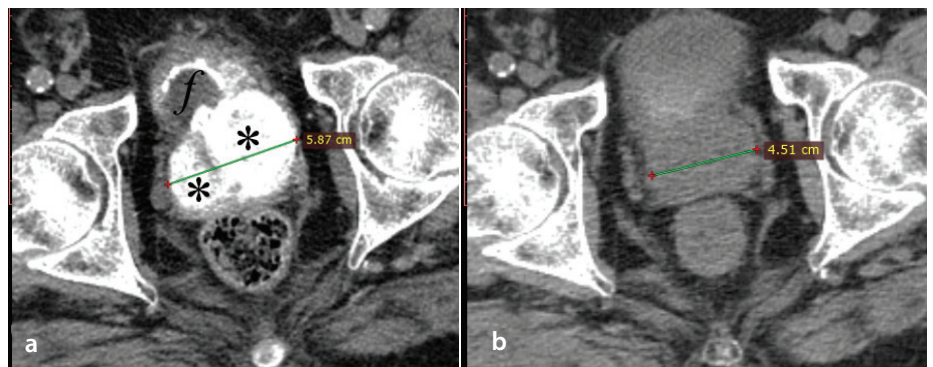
(Images published after patient's informed consent). (a, b) Representative axial computed tomography (CT) images from a successful prostatic artery embolization (PAE) case in the comparative study (patient with an indwelling bladder catheter). CT immediately post-PAE with 40–120 μm Embosphere microspheres (a) shows extensive, dense accumulation of the contrast-microsphere mixture in both prostatic lobes (*). The balloon of the bladder catheter is noted by "f". Contrast-enhanced ultrasound 1 day post-PAE (not shown) demonstrated extensive prostatic infarction (percentage of prostatic ischemia: 80%). Forty months post-PAE, the patient remains catheter-free, and CT (b) shows significant, durable prostate shrinkage.
